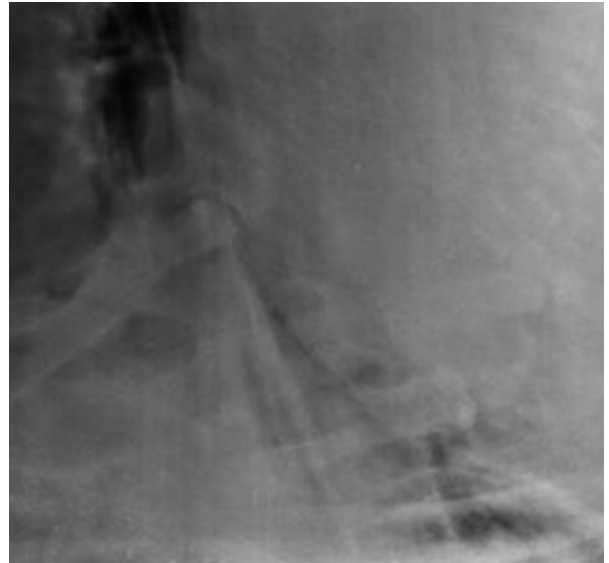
Radiograph of the reticular region taken immediately after removal of foreign body.
